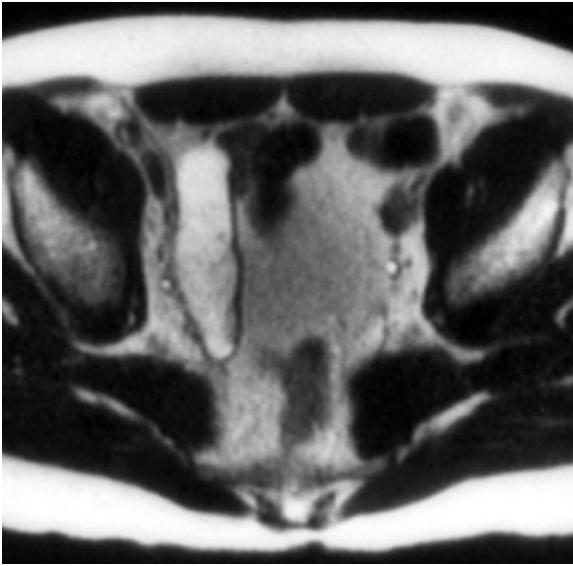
MR appearance of a benign mucocoele. T2-weighted MR image through the pelvis shows a high signal intensity blind-ending lesion consistent with an appendiceal mucocoele, which was confirmed to be a benign mucinous adenoma
